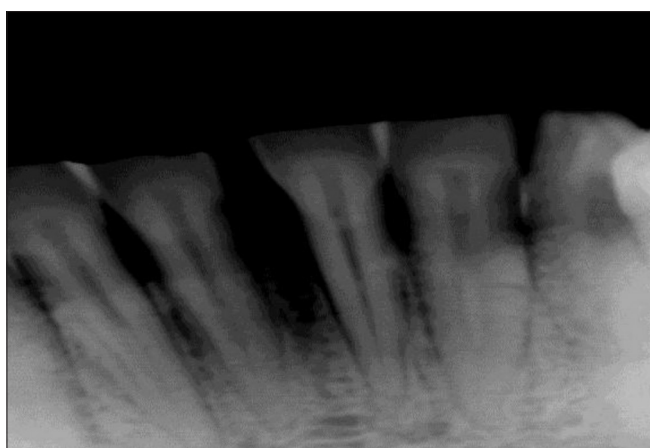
Radiographic picture
